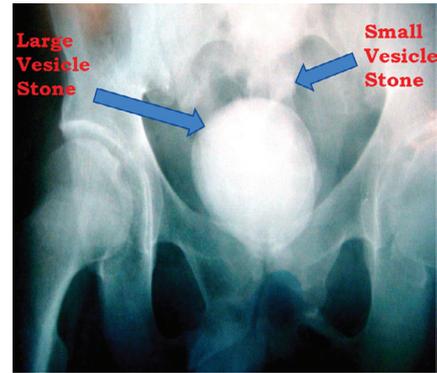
Pelvic x-ray showing a huge vesical stone.
